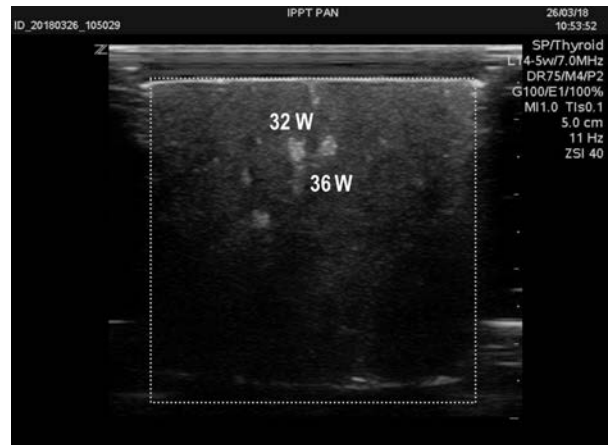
Ultrasound image of the axial section (*xz*) of the tested tissue sample placed in the cylindrical chamber after its exposure to two parallel, spaced by 4 mm, HIFU beams with the acoustic power of 32 W and 36 W.
